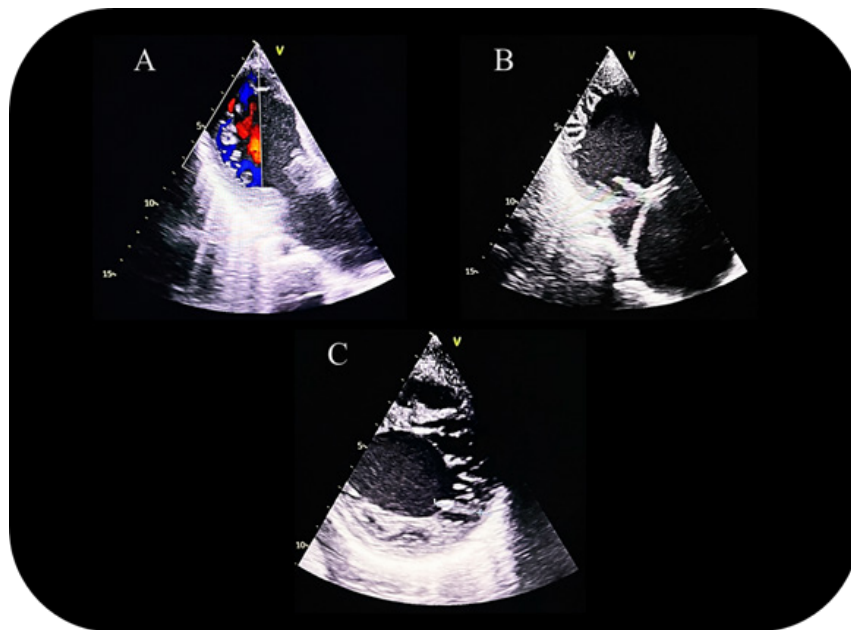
Transthoracic echocardiography demonstrating hypertrabeculation of the RV free wall. A) Apical view with color Doppler imaging. B) Two-dimensional apical view demonstrating prominent trabeculations. C) Parasternal short-axis view demonstrating hypertrabeculation of the RV free wall. RV: right ventricle.
